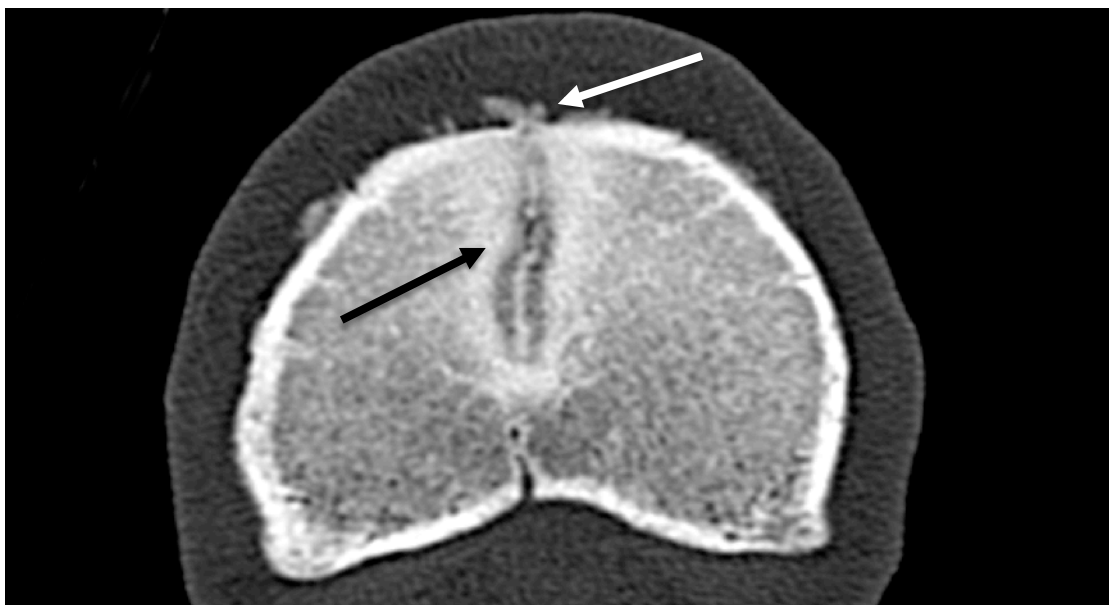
Transverse CT view of the same SCL showing a clear short incomplete fissure (black arrow) with involvement of the dorsal cortex as well as moderate dorsal periosteal reaction (white arrow). This CT image shows the typical appearance of an SCL in conjunction with a small fissure line with a long split-like opening to the joint surface.
